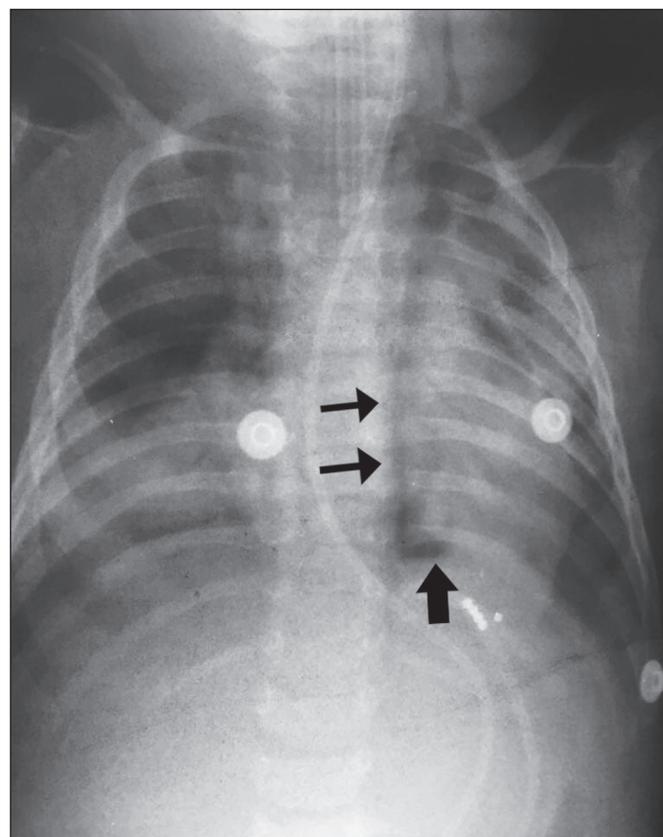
The V sign of Naclerio. A one-year-old male, hospitalized with a diagnosis of pneumonia in the lower left lobe, with no satisfactory response to treatment. After the insertion of a nasogastric tube, there was worsening of the clinical status, a chest X-ray showing the V sign of Naclerio and suggesting a diagnosis of esophageal rupture with pneumoperitoneum. Vertical branch (thin arrows) and horizontal branch (thick arrow).
